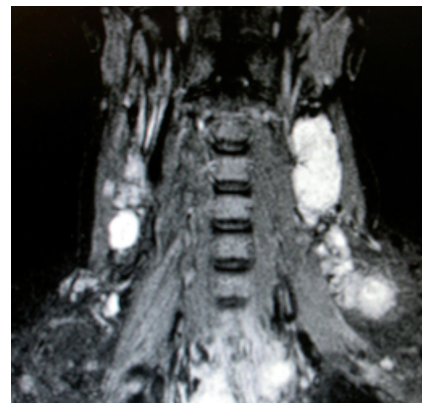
MRI scan of a patient with extensive lymphadenopathy from a papillary thyroid carcinoma.
